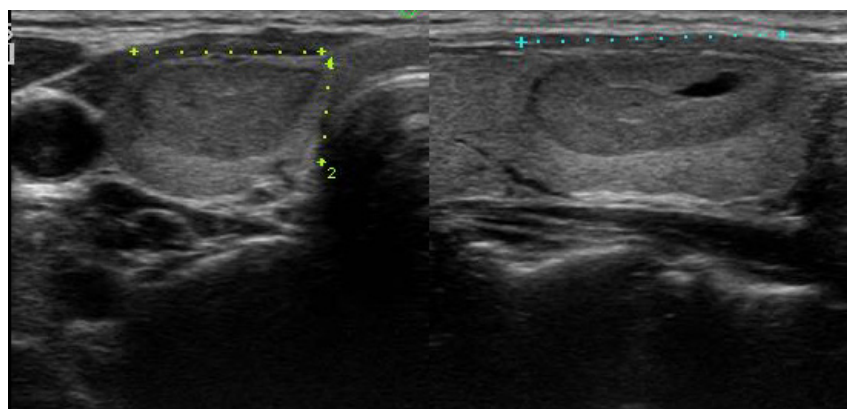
Ultrasound images show a well-demarcated thyroid nodule.
